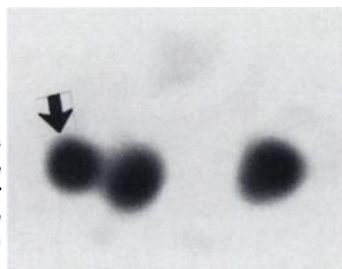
Indium-111-OCT (130 MBq, 6 hr SPECT image, transverse slice) shows focally increased tracer uptake in the right liver lobe (arrow) corresponding to the liver lesion seen on CT.
